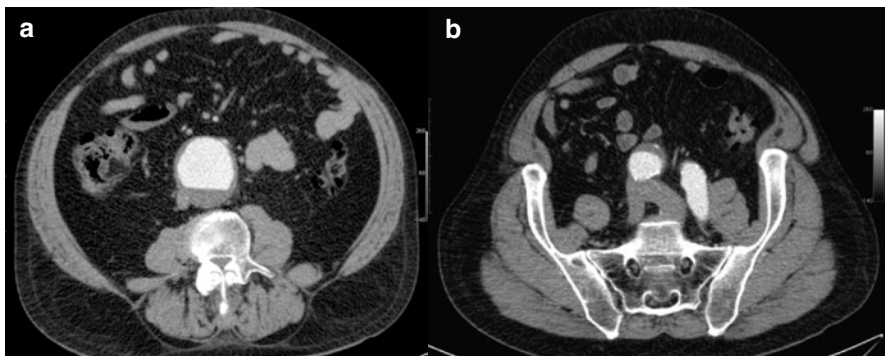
(a and b): CT scan demonstrating the aortic aneurysm as well as the right common iliac aneurysm
